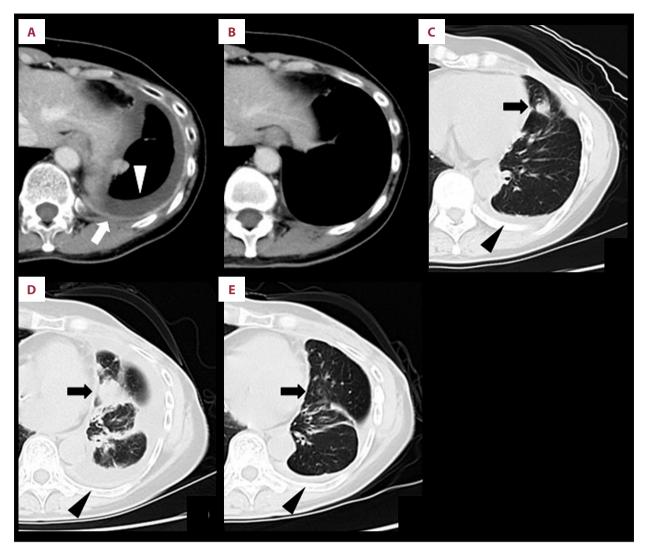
Changes in the pleural effusion, pleural thickening, and lung metastasis on CT. E-CT in May 2017 (A) showed the pleural effusion (white arrowhead) and pleural thickening (white arrow). E-CT 5 months later (B) revealed disappearance of pleural effusion and pleural thickening. On CT in January 2019 (C), left pleural effusion was observed again (black arrowhead) and a nodular shadow appeared in the lingular division of the left lung (black arrow). CT in September 2019 (D) revealed increased pleural effusion (black arrowhead) and an enlarged nodular shadow (black arrow). E-CT performed after receiving of RF hyperthermia (E) showed disappearance of lung metastasis (black arrows) and decrease in pleural effusion (black arrowheads).
